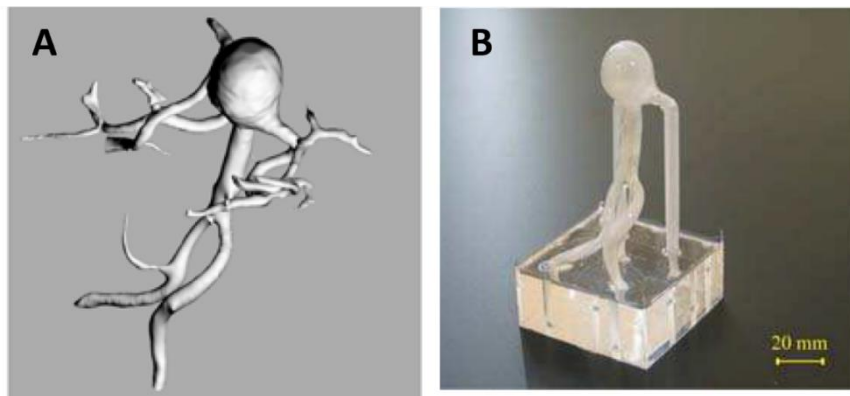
(A) 3-D structure of basilar tip artery with giant aneurysm reconstructed with CT angiography. (B) An in vitro patient-tailored biological model of human cerebral artery with vasculature-like thin uniform membranous configuration [163].
